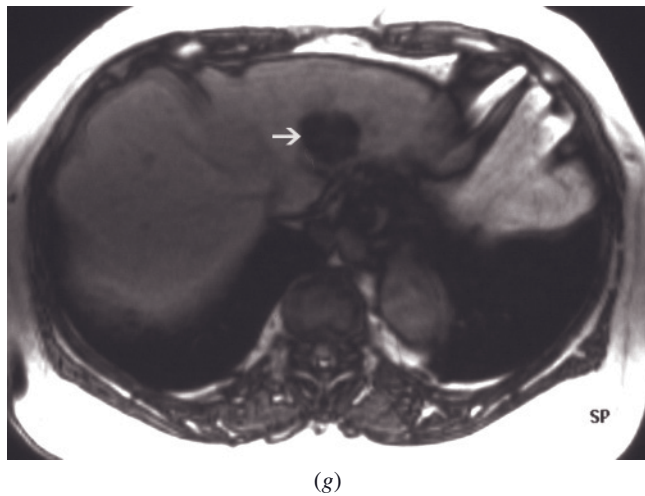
(Continued) SGE (*f*), out-of-phase SGE (*g*), and immediate (*b*) and 90-s fat-suppressed (*i*) postgadolinium SGE image in a second patient. There are two rounded lesions situated side by side in the left hepatic lobe. The nodule adjacent to the middle hepatic vein demonstrates low signal intensity on T1-weighted image, intense enhancement on early-phase image (arrow, *b*), and washout with capsule enhancement on late-phase image (*i*). This HCC does not show drop in signal intensity on out-of-phase image (*g*). The tumor located near the left hepatic vein has similar imaging features, but it drops in signal intensity on the out-of-phase image (arrow, *g*), consistent with the presence of fat within the HCC.
